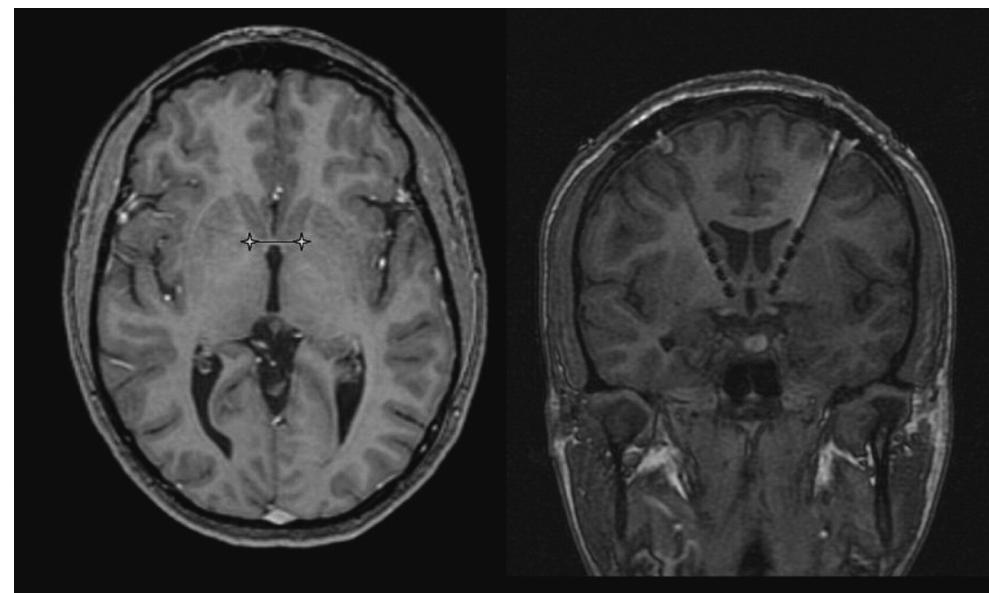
Axial magnetic resonance image on the left demonstrates bilateral target locations at the junction of internal capsule and anterior commissure, which corresponds to the nucleus accumbens (NAcc) region. Coronal image on the right shows contact zero in NAcc and dorsal contacts within ventral capsule/ventral striatum. Reprinted with permission from Malone et al.²⁹
